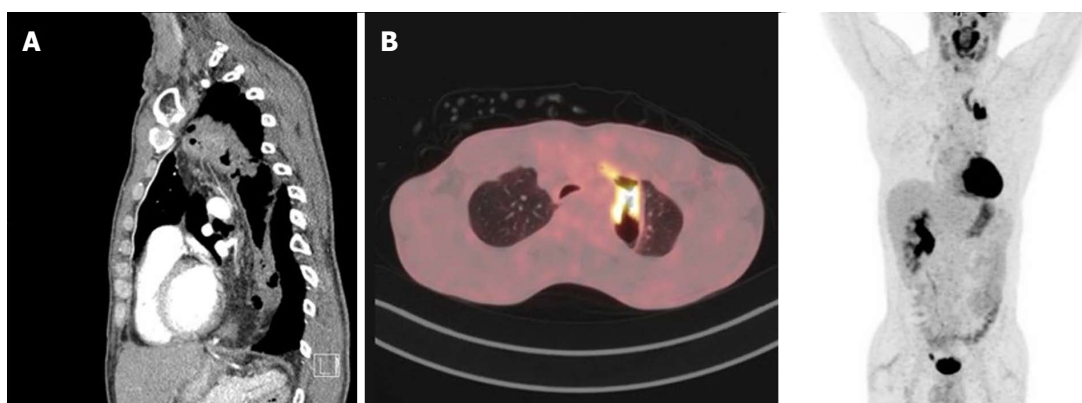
Initial findings at positron emission tomography-computed tomography scan (PET-CT scan) (case 4). A: Chest CT scan image with a circumferential wall thickening of the thoracic colonic interposition over a length of 10 cm, not clearly separated from the thyroid and left brachiocephalic vein. Locoregional suspected lymph nodes (< 1 cm). B: PET-CT scan showing a PET-positive lesion in the thoracic colonic interposition. No PET-positive lesions or lymph nodes.
